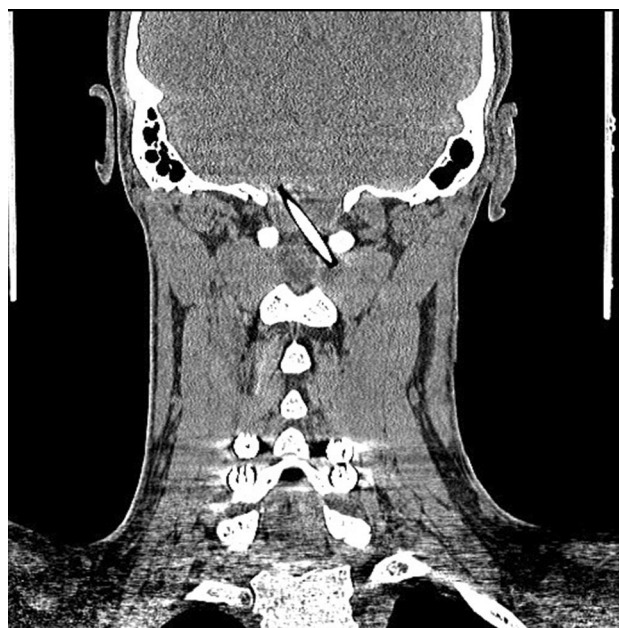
CT cervical spine (coronal view). Position of the dislodged rod near the Foramen magnum
